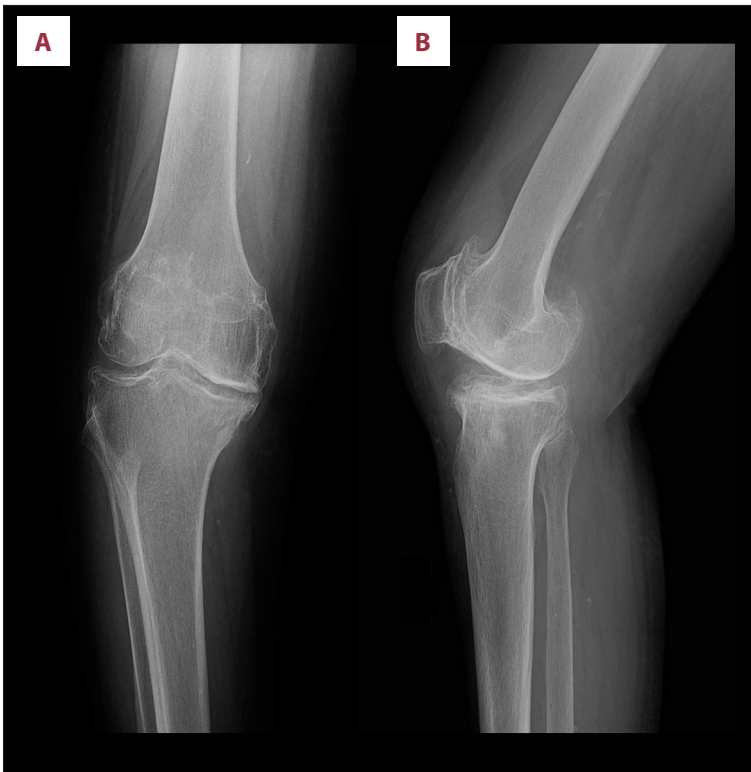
Preoperative radiograph of the right knee (Case 1), anteroposterior (A) and lateral (B) views.
